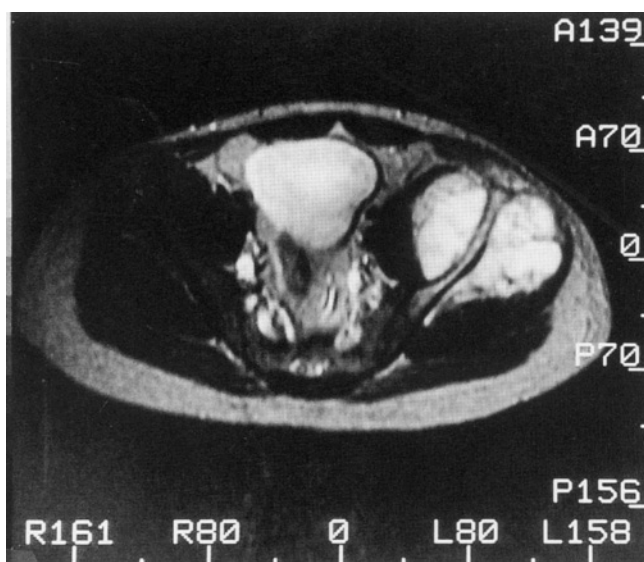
MRI scan of an osteosarcoma stage IIB involving the entire wing of the ilium with extension to the superacetabular area. This patient underwent a classical hemipelvectomy.
